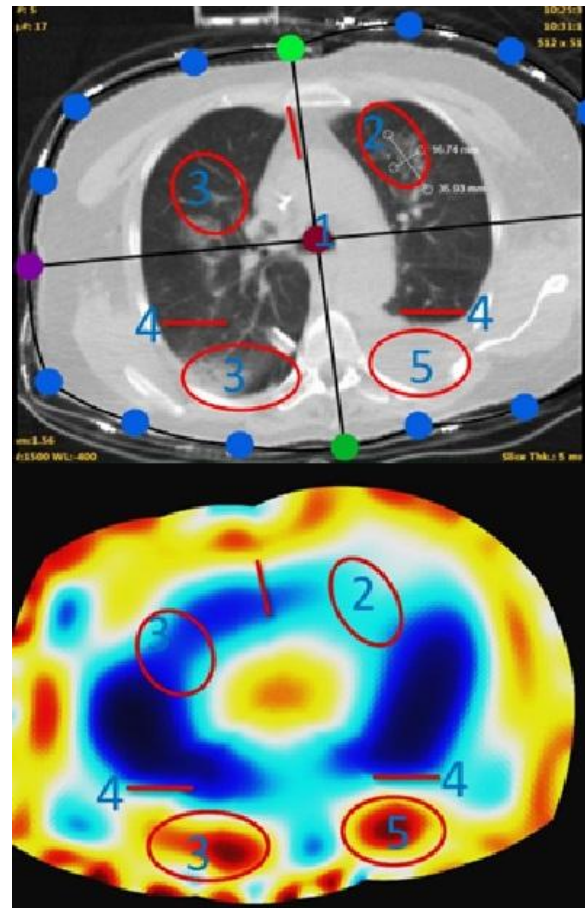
Comparison between CT scan image and the personalized reconstructed EIT image of patient 1
